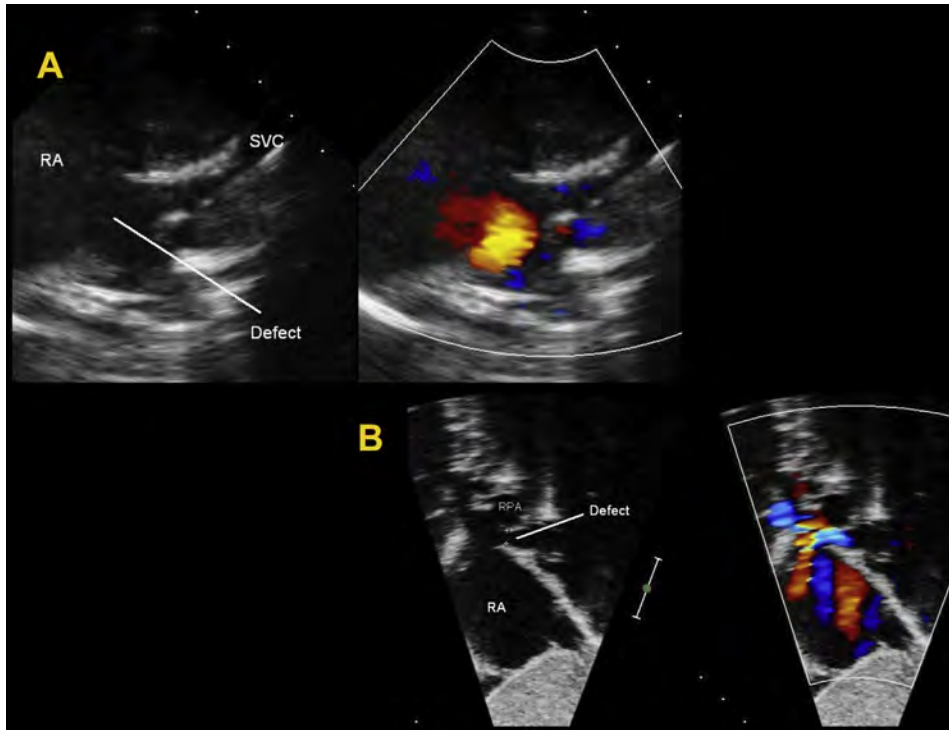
(A) Representative example of 2D TTE (*left*) and with color Doppler (*right*) of an SVC type sinus venosus ASD from the high right parasternal view. (B) Representative example of 2D TTE (*left*) and with color Doppler (*right*) of an SVC type sinus venosus ASD from the subcostal sagittal view. RPA, right pulmonary artery. See also [Video 8](#).
